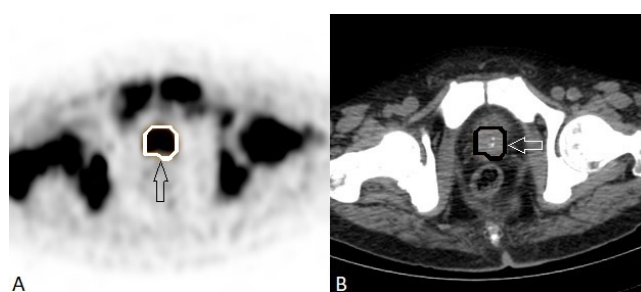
^{68}Ga -PSMA PET/CT axial PET (A) and axial CT (B) images. A volume of interest was drawn around the prostate lesion (arrow) ^{68}Ga -PSMA: ^{68}Ga -prostate-specific membrane antigen, PET/CT: Positron emission tomography/computed tomography
